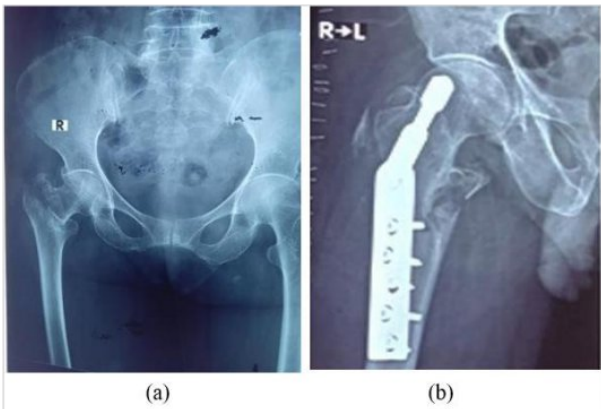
(a) Preoperative anterior-posterior view of an intertrochanteric fracture. (b) Immediate postoperative lateral X-ray showing DHS fixation in the right proximal femur.
